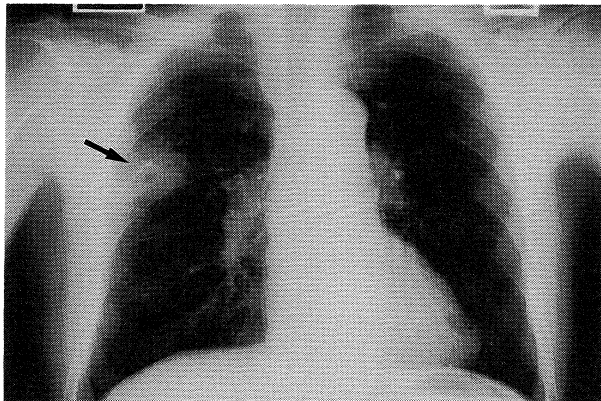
Chest X-ray showing an ill-defined density in the right upper lobe (arrow).
